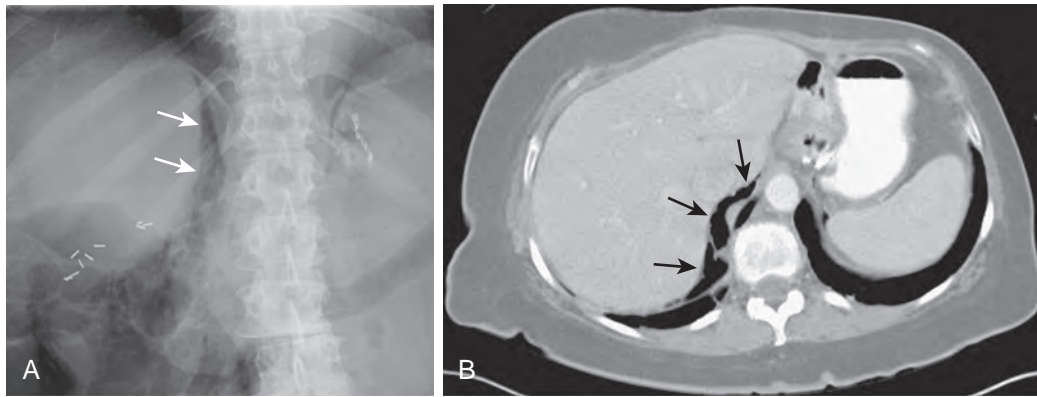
Retroperitoneal air in a patient with retroperitoneal perforation after endoscopy. A. Retroperitoneal air is manifested by linear gas collections (arrows) dissecting along the right margin of the psoas muscle in the upper retroperitoneum to the undersurface of the medial aspect of the right hemidiaphragm. B. CT confirms the retroperitoneal location of this extraluminal air (arrows). (Courtesy Laura R. Carucci, MD, Richmond, VA.)
